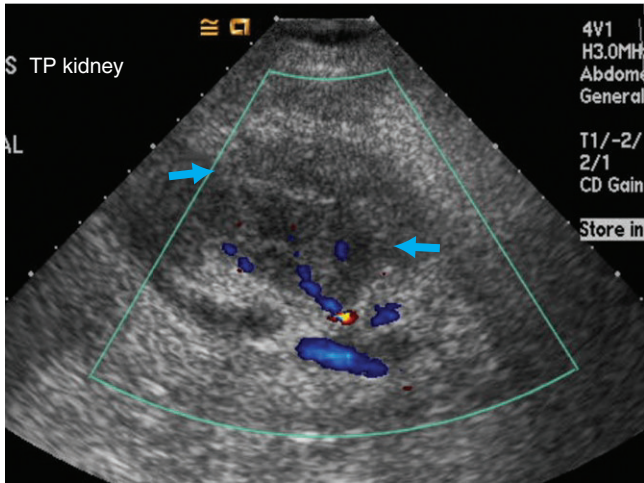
Color Doppler ultrasound image demonstrates an echogenic collection superior to the kidney. Poorly vascularized kidney can be identified separately from the avascular hematoma. An interface between the hematoma and the underlying kidney is demonstrated (arrows).
